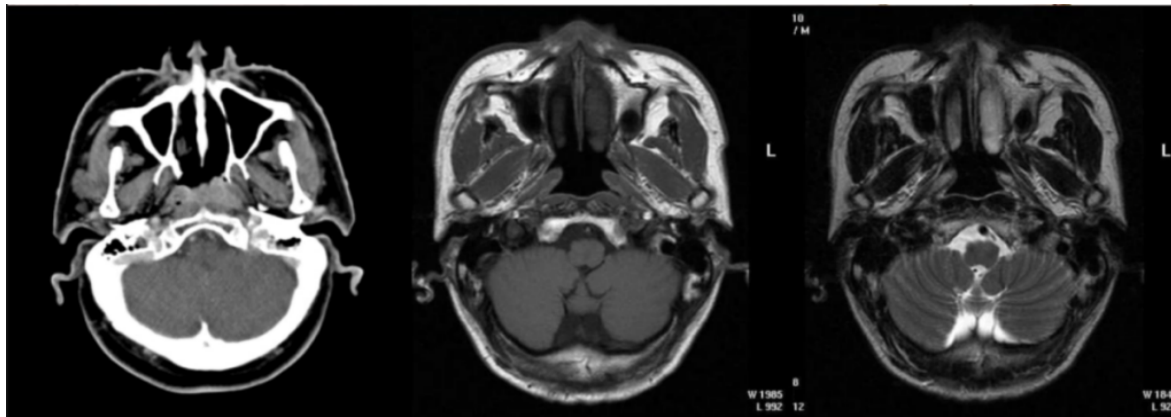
MRI images under different windows.
